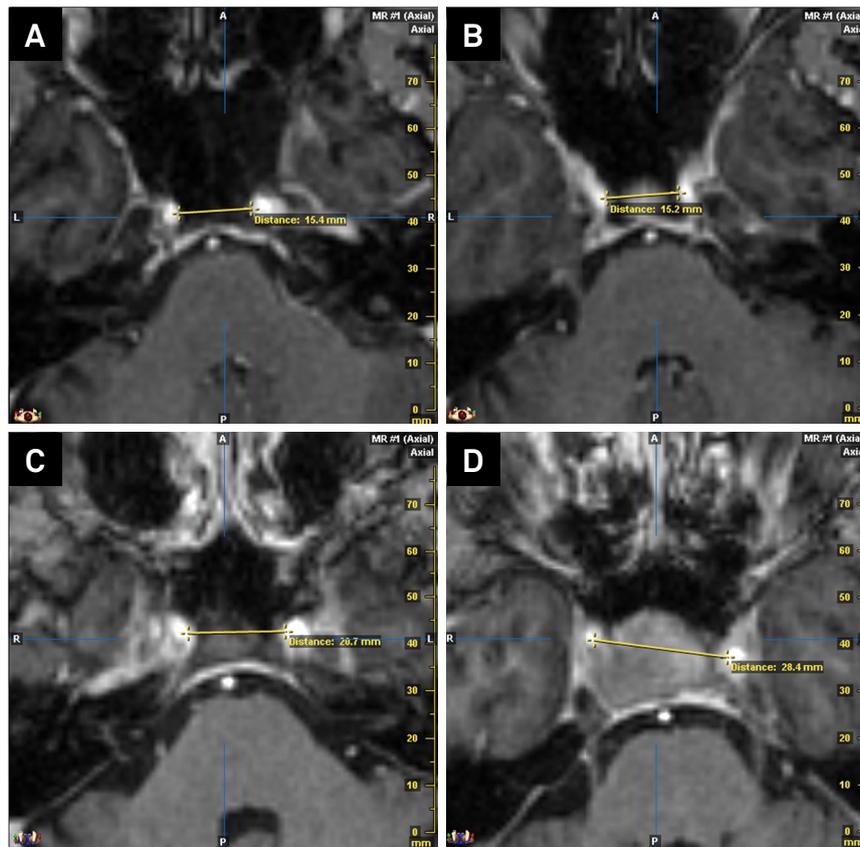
T1-weighted gadolinium enhanced axial MRI of the sellar and parasellar regions comparing the ICDs between the control (left) and its paired patient with adenoma (right). (A) ICD1 and (B) ICD2 of patient 39; (C) intercarotid distance 1 (ICD1) and (D) intercarotid distance 2 (ICD2) of patient 19.
